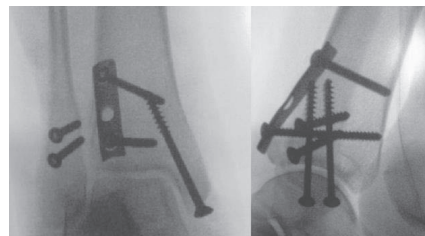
Postoperative x-rays showing anatomical reduction and fixation with buttress plate.
